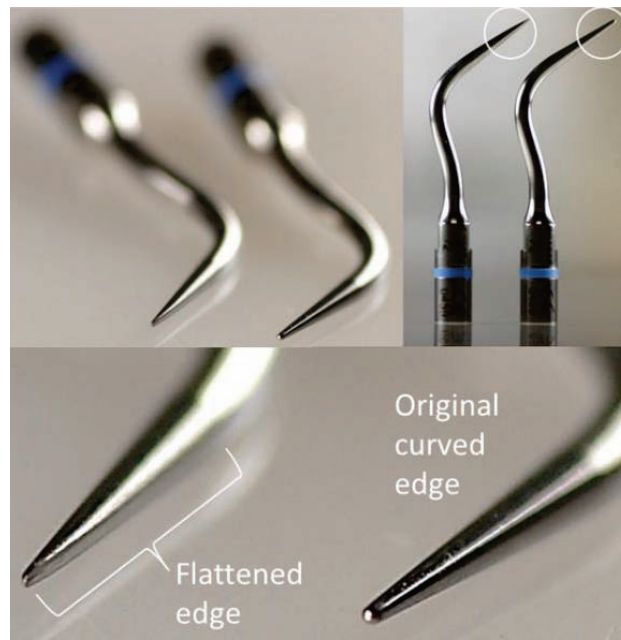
Photographs of the original and modified versions of the ultrasonic scaler tip used in this study.
